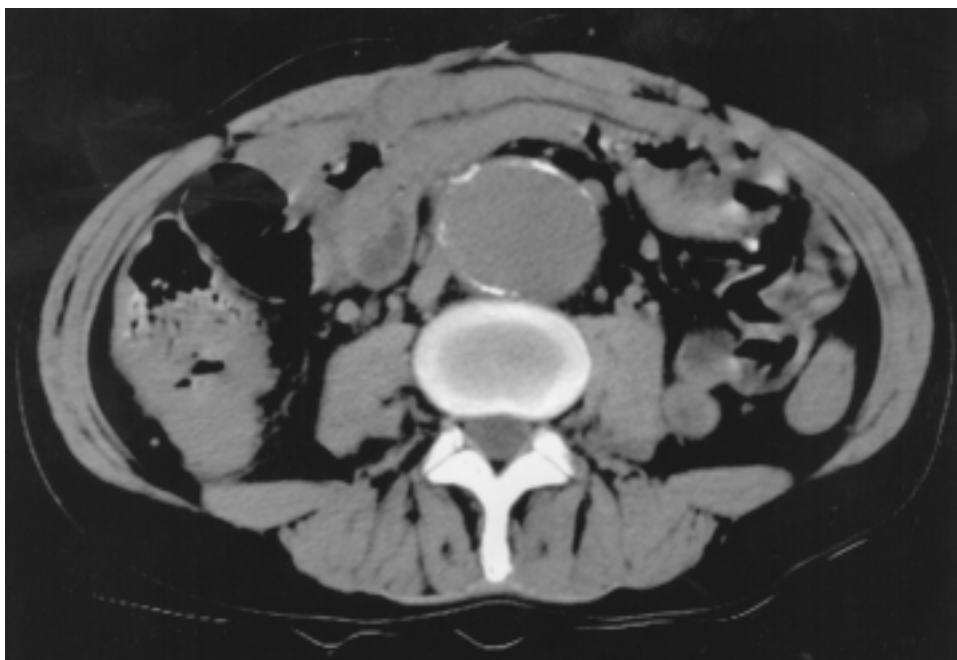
Nonenhanced CT scan shows a 5-cm infrarenal AAA without evidence of leak or rupture.
